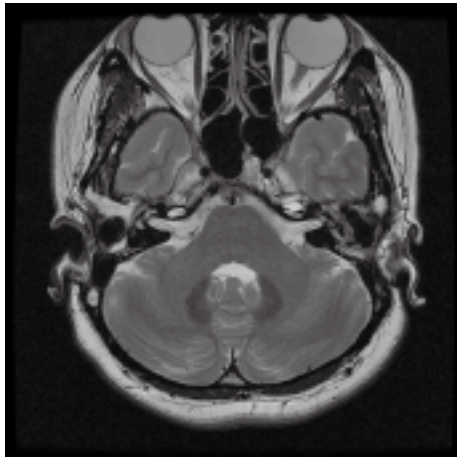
Contrast-enhanced MRI of the inner ear.
